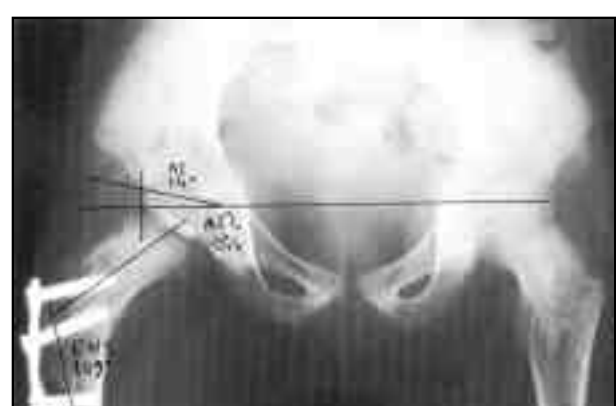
Case No. 1, Postoperative X-rays after 16 months showing a good result
